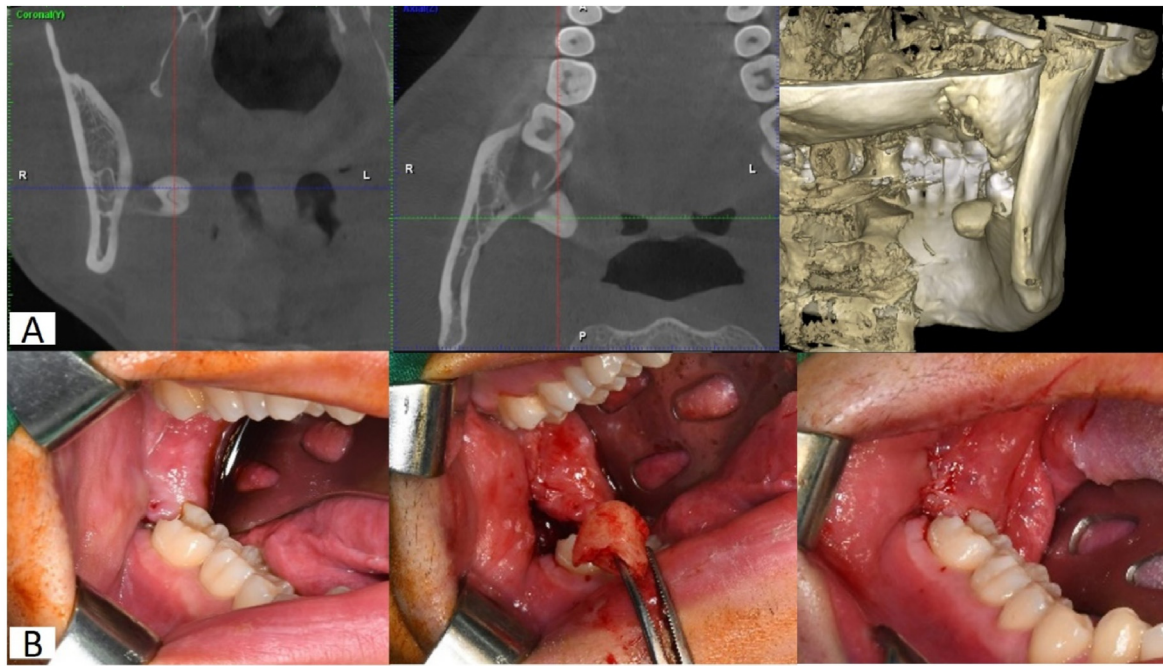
The cone-beam computed tomography and clinical photographs of our case. (A) The cone-beam computed tomography showing the lingually displaced root fragment in our patient. (B) Surgical procedures and photographs demonstrating the removal of the lingually displaced root fragment during the operation.
